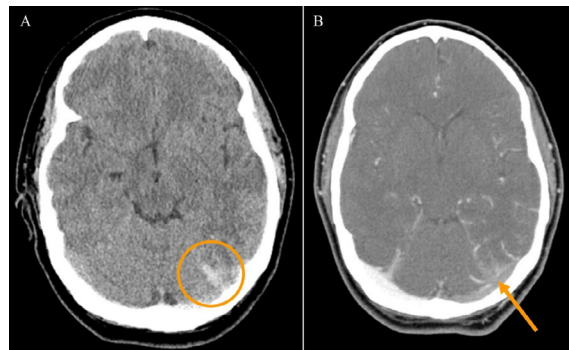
(A) CT head without contrast showing abnormal asymmetric hyperdensity involving the left transverse (orange circle) and sigmoid sinus. (B) CT venogram head with contrast showing acute CVT propagating from the sinus confluence through the left transverse (orange arrow) and sigmoid sinus.
